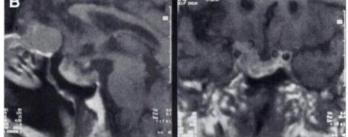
lodine-123-epidepride SPECT 3 hr p.i in prolactinoma Patient 3. Specific binding in the lower and more central focus (top row) corresponded to an intrasellar adenoma, binding in a second, more frontal and left focus (upper right and three lower left slices) was due to a frontobasal tumor extending from the anterior skull base to the falx. Four bottom slices display striatal binding (A). Corresponding sagittal MRI image (left) showing an enlarged sella with the intrasellar adenoma and the frontobasal tumor and coronal MRI image (right) displaying the intrasellar tumor and its parasellar extension (B).
